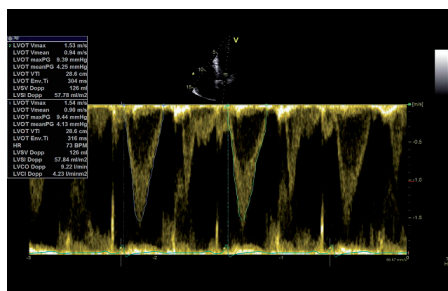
Pulsed-wave Doppler recordings performed approximately one cm below the aortic valve.
